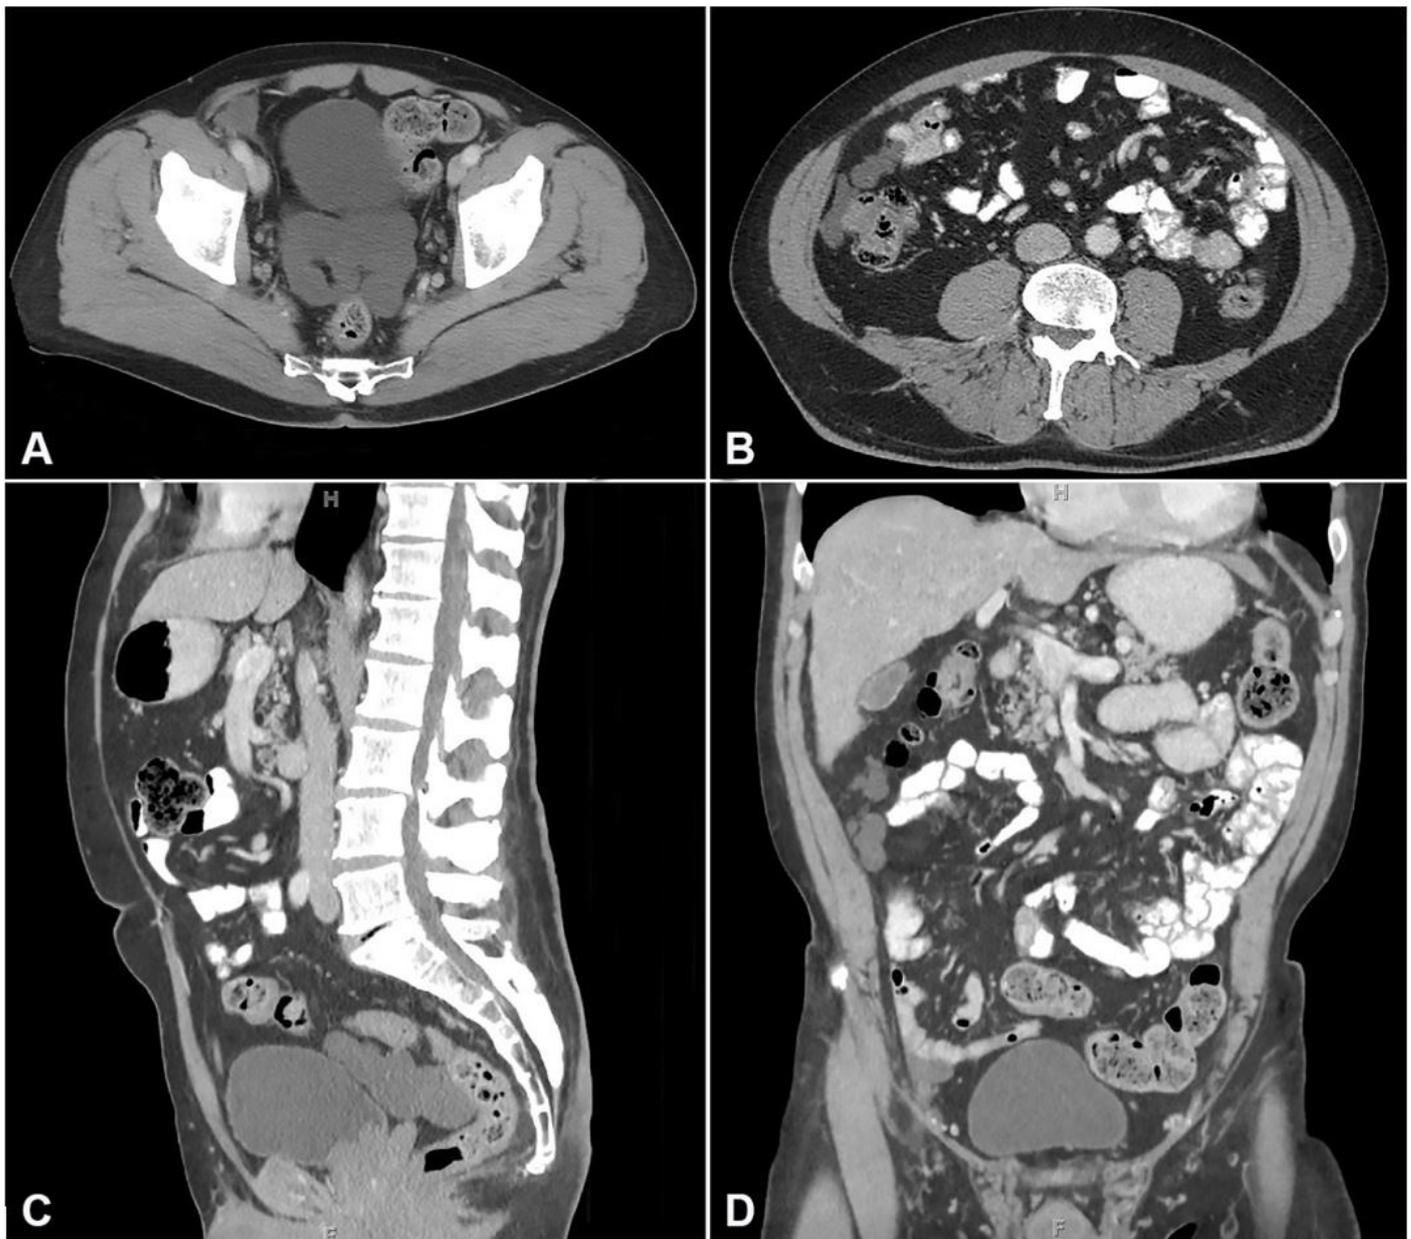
Abdominal contrast-enhanced CT scan of BMPM. A – Axial Post-Contrast CT demonstrating cystic lesion posterior to the urinary bladder; B – Axial Post-Contrast CT demonstrating cystic lesion in the right para-colic gutter; C – Sagittal Post-Contrast CT demonstrating cystic lesion posterior to the urinary bladder; D – Coronal Post-Contrast CT demonstrating cystic lesion in the right para-colic gutter.
